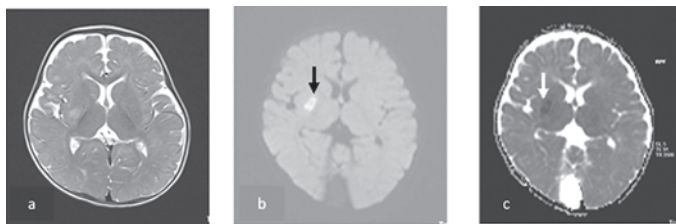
Axial T2WI (a) Hyperintensity in right posterior putamen. DWI MR (b) and corresponding ADC mapping (c) Diffusion restriction in right posterior putamen in a child with mineralizing angiopathy of lenticulostriate arteries.
